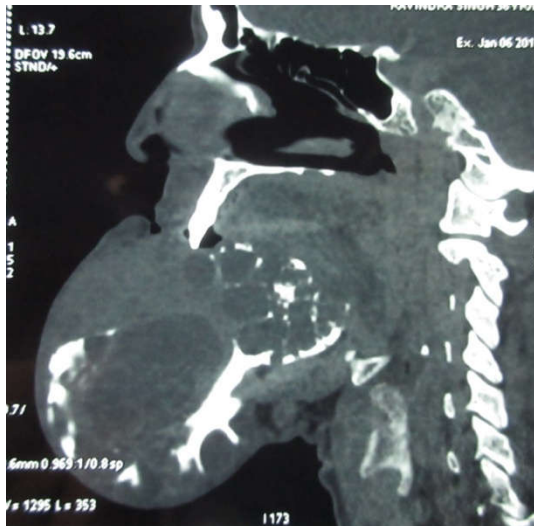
CT scan showed gross cortical expansion & compromised nasopharyngeal airway.
